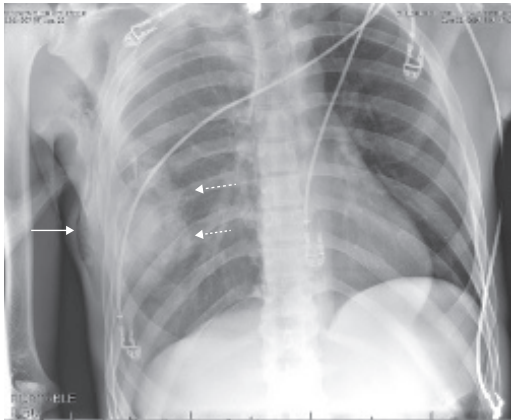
Fifteen-year-old male with penetrating trauma to the chest. Radiograph shows subcutaneous emphysema (solid arrow), 7th to 8th rib fractures (dashed arrows), and hemothorax with increased opacification of right lung fields.
